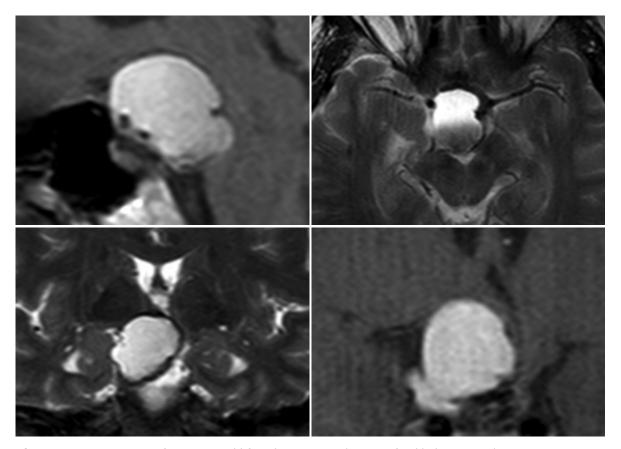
Preoperative MRI of a 56-year-old female patient with transinfundibular craniopharyngioma (Kassam II)
